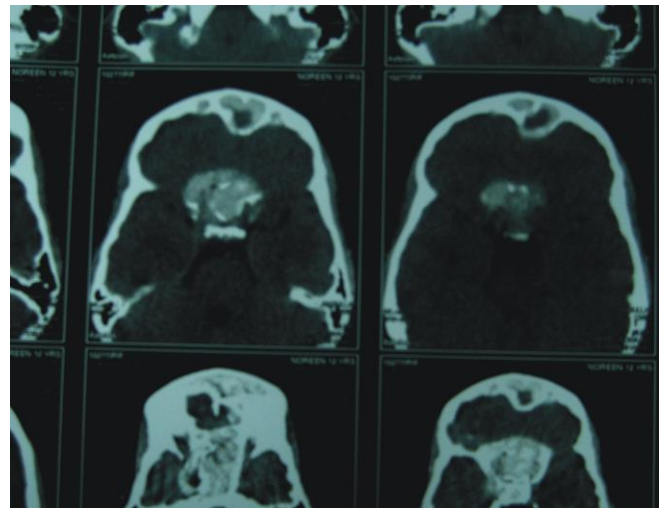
CT scans paranasal sinuses and brain showing heterogeneous lesion (Fungus) with intracranial extension.
